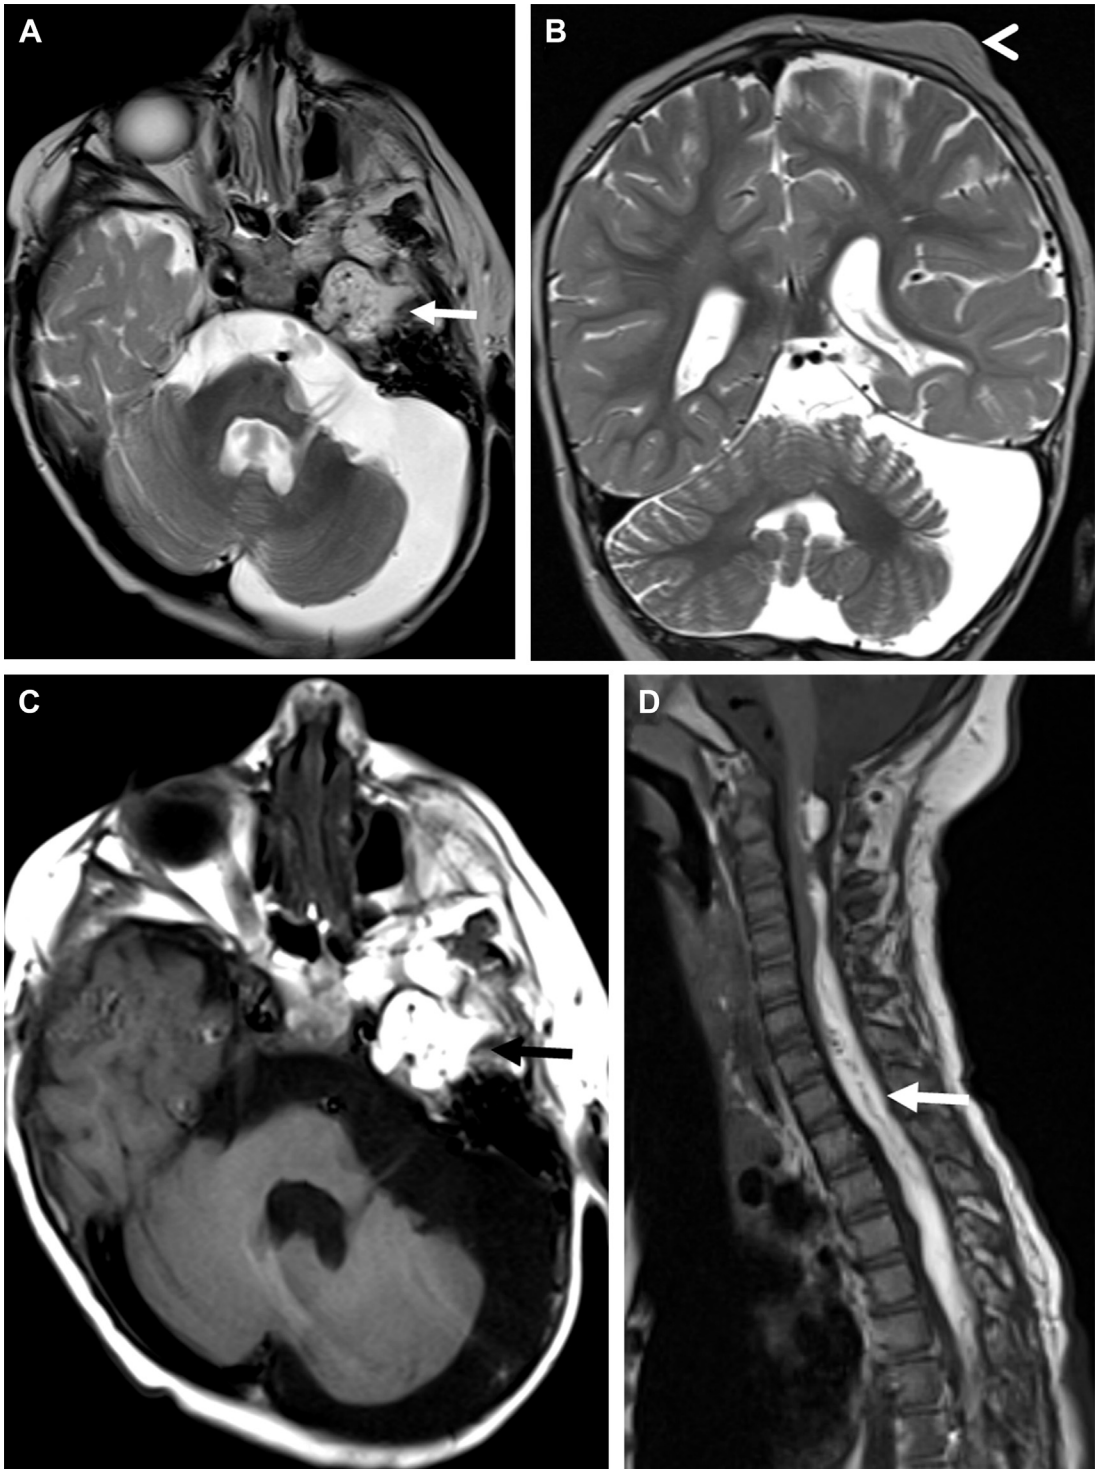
ECCL. Axial and coronal T2-weighted images showing left cerebellar hypoplasia with prominent CSF space subjacent to left cerebellar hemisphere. (A) Intracranial lipoma infiltrating the left petrous temporal bone (*arrow*) and (B) scalp lesion (*arrowhead*). (C) Axial T1-weighted image demonstrates left cerebellar hypoplasia and T1 bright lipoma (*black arrow*) infiltrating the left petrous temporal bone. (D) Sagittal T1-weighted image of the cervical spine showing epidural location of intraspinal lipoma (*arrow*).
